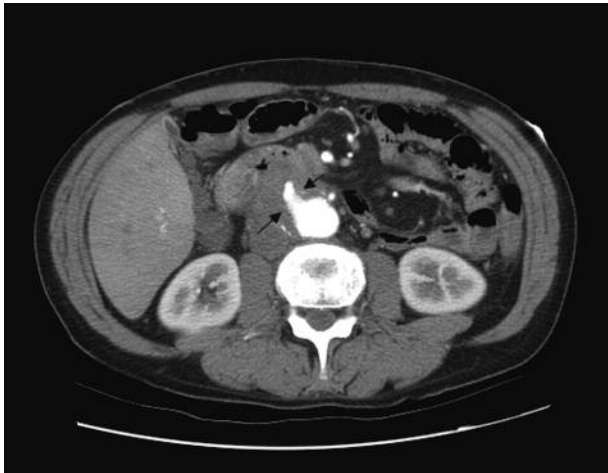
CT scan of abdomen showing contained perforation of the infrarenal portion of the abdominal aorta with the aortoenteric fistula (arrows).
